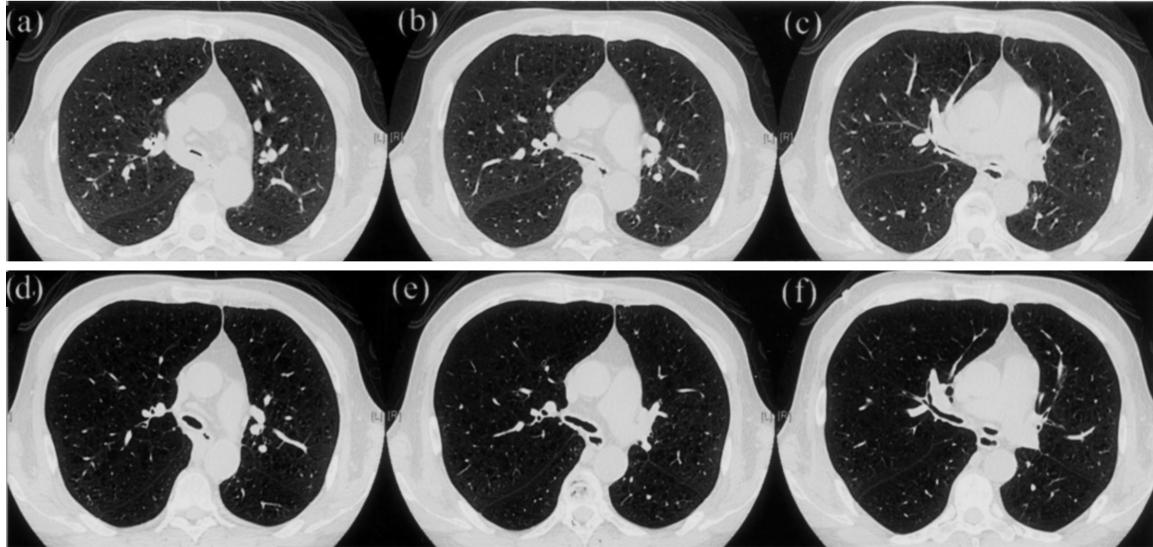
High-resolution CT showed extreme tracheal luminal narrowing during the expiratory phase, especially at the (a) distal trachea, (b) carina, and (c) bilateral main bronchi, compared to the inspiratory phase at the (d) distal trachea, (e) carina, and (f) bilateral main bronchi.
